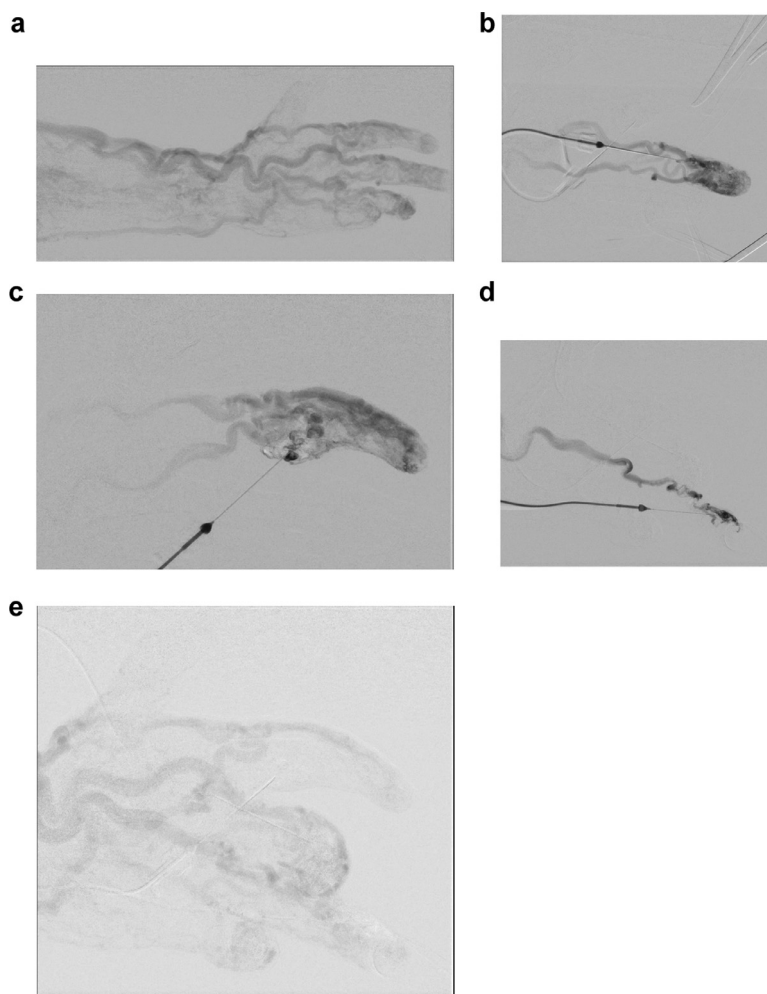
Patient with an upper arm AVM. (a,b) Diffuse arterioles and venules in the 2nd, 3rd and 4th fingers classified as Cho IIIa or Yakes IV. (c to e) Direct puncture of the nidus under ultrasound guidance and injection of intranidal bleomycin. (e) Control DSA showing a good improvement of the shunting especially in the 2nd and 4th fingers. Flexion of the third finger explains poor visualization of the distal phalanx.
